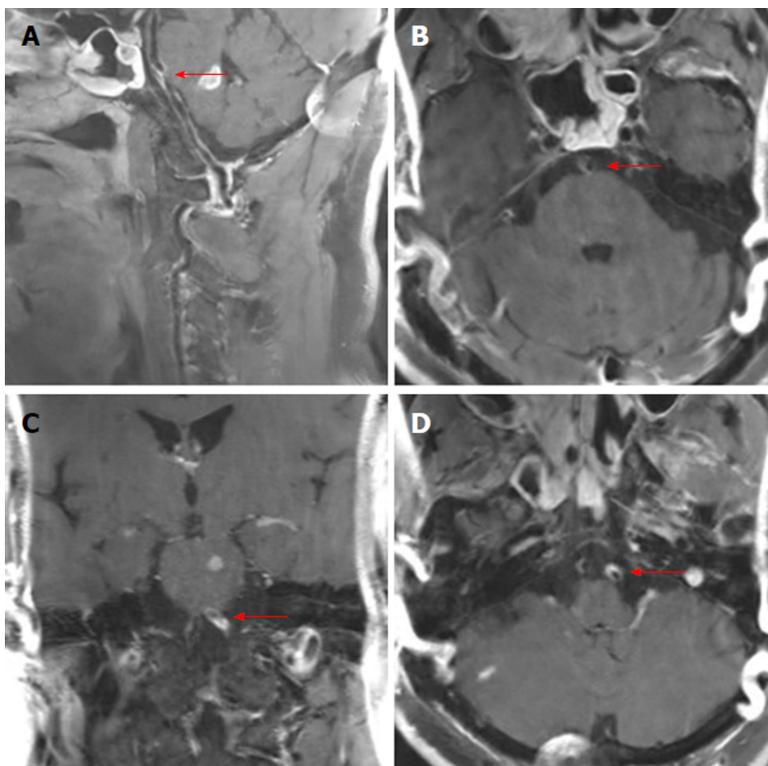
High-resolution magnetic resonance imaging shows the dissection of the basilar artery and left vertebral artery. A, B: The eccentric periluminal hematoma of the basilar artery; C, D: The eccentric periluminal hematoma of the left vertebral artery.
